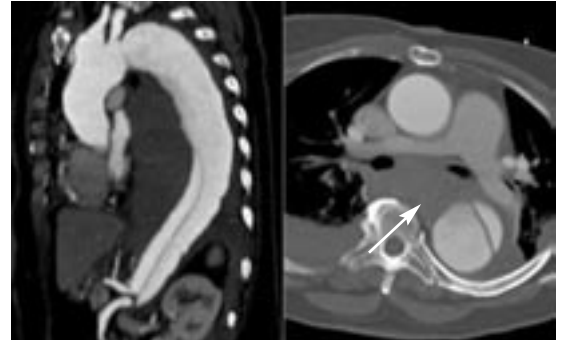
A coronal reformatted image (left) and an axial image (right) from contrast-enhanced, cardiac-gated CT in a patient who presented with acute aortic syndrome show a type B aortic dissection extending from the aortic arch (distal to the arch vessels) into the abdomen. Hemorrhage from recent rupture is seen in the left and right hemithorax and in the mediastinum (arrow).
